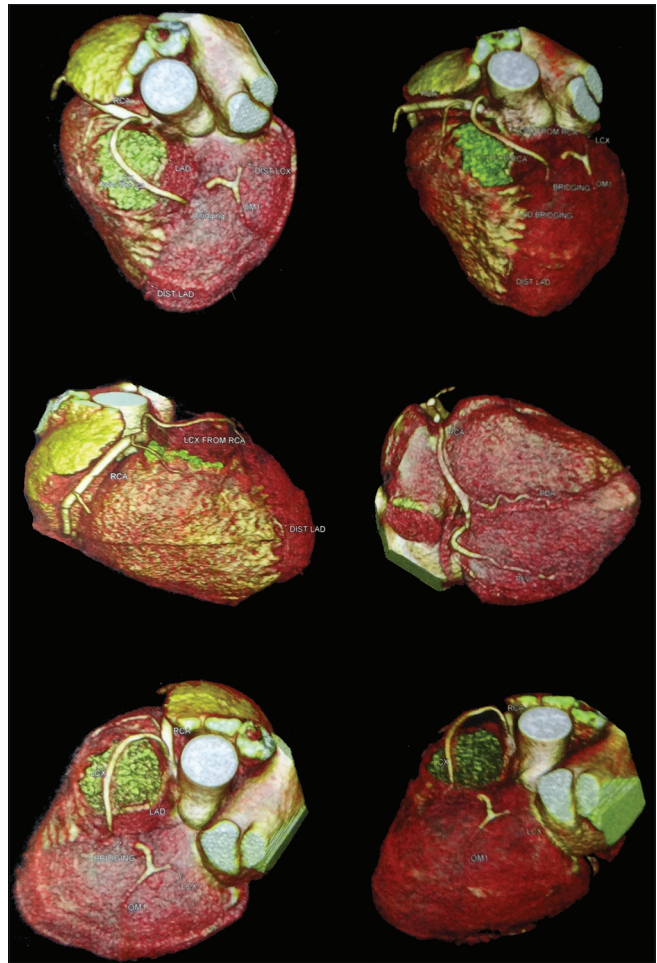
Three-dimensional image reconstruction from computed tomography scan showing the anomaly
